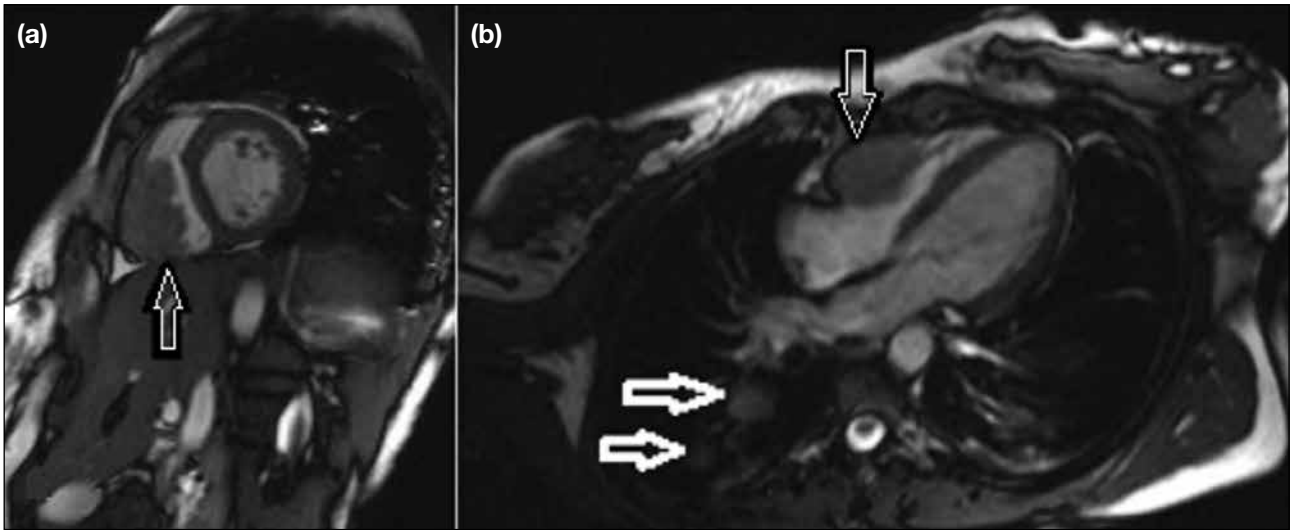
Two-chamber cardiac magnetic resonance image of a 52-year-old female patient diagnosed with uterine leiomyosarcoma (a). The mass is contiguous and indistinguishable from the right ventricular wall (black arrow). (b) A four-chamber image demonstrates the metastatic lesion (black arrow) in the right ventricle. The patient presented with several metastases, and two of them are clearly seen in the posterior right lung (white arrows).
